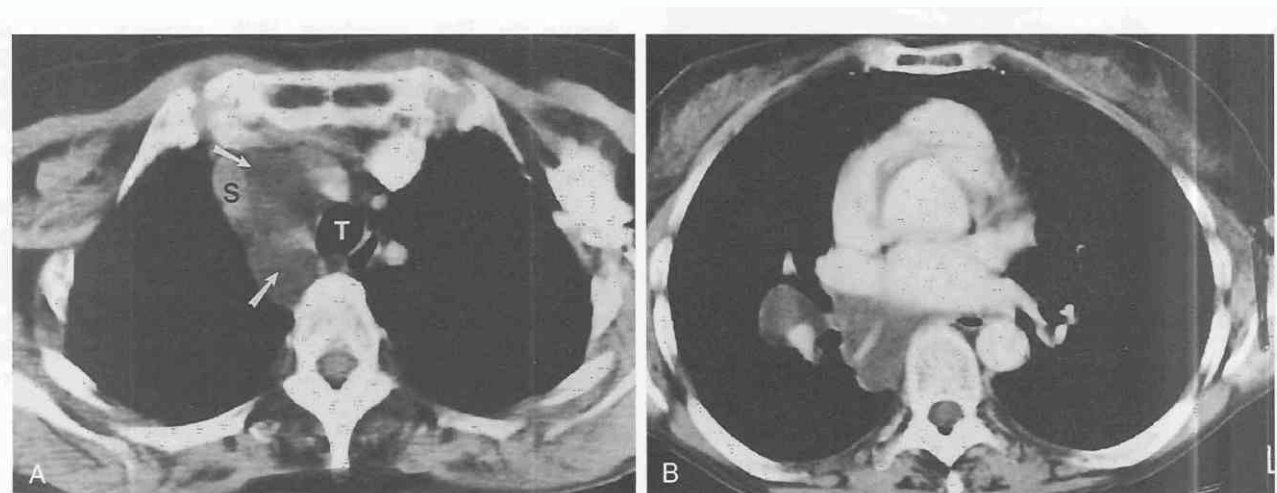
Lymphangioma. A, Contrast-enhanced CT shows homogeneous, water-attenuation mass (arrows) in superior mediastinum, which arose in the neck. S, superior vena cava; T, trachea. B, The mass diffusely infiltrates mediastinum and extends into the right hilum.
